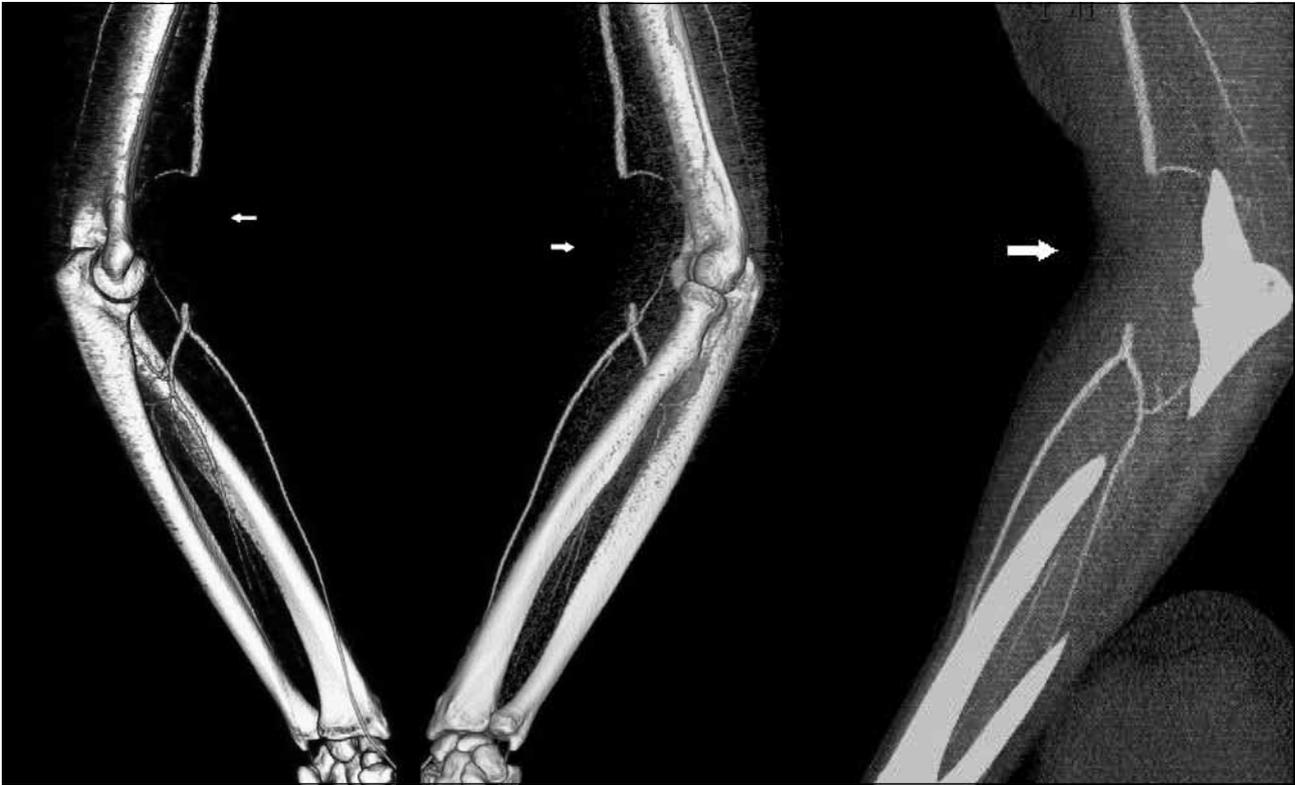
3-Dimensional volume-rendered computed tomographic angiography image and reconstructed image in maximal intensity projection showing truncated brachial artery above the bifurcation (arrows) with reconstitution of distal flows by collateral branches.
